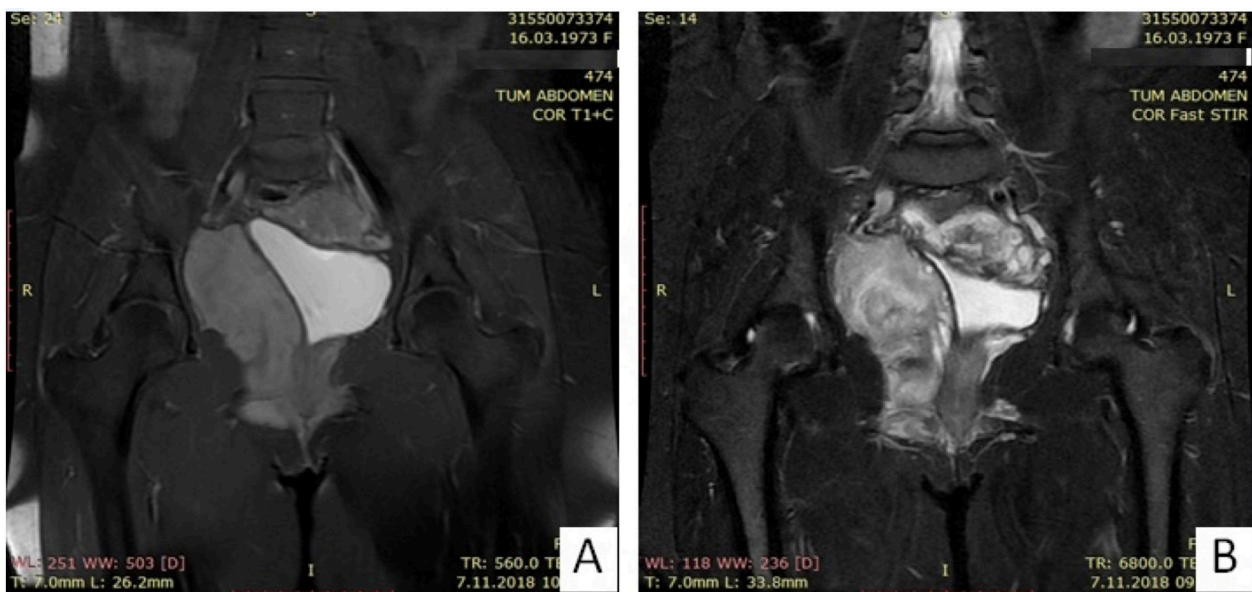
Coronal images of the pelvis with MRI prior to surgical treatment.
